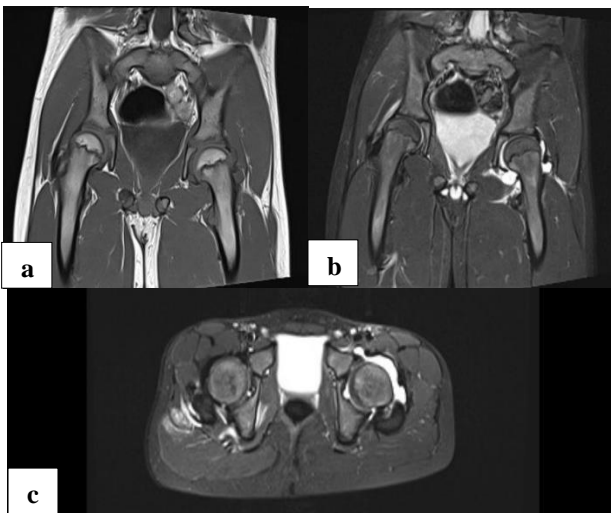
(a)-(c) MRI hip joint contrast.
